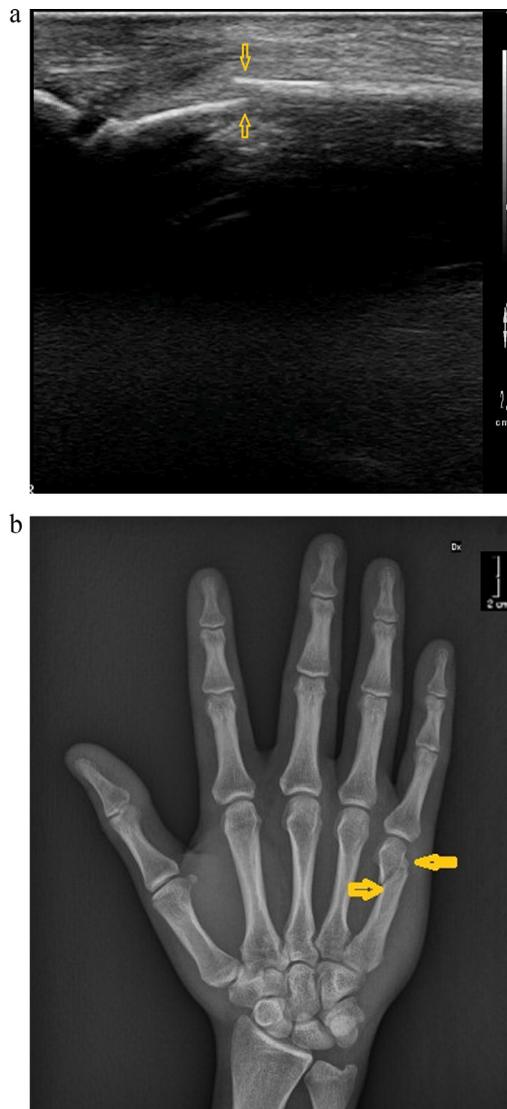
(a) Ultrasound image of the fifth metacarpal with obvious stop-off. *Yellow arrows* point to the discontinuity of the cortical bone, expression of fracture. (b) X-Ray image of fifth metacarpal from (a) with obvious deformity. The *yellow arrow* points to the discontinuity of the cortical bone, expression of fracture.
